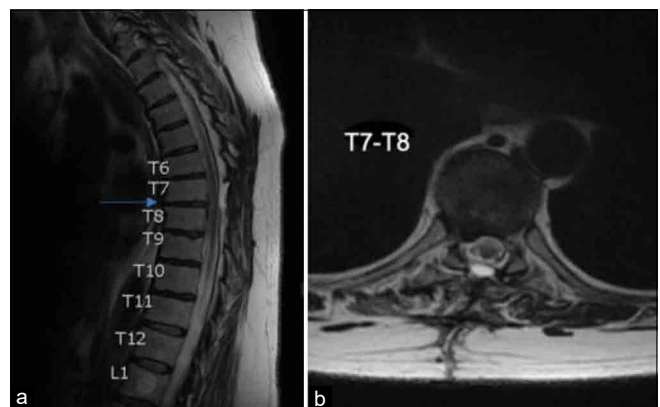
Postoperative MRI thoracic spine. (a) Sagittal view; arrow pointing to the level of the prior spinal cord herniation at T7-8, (b) Axial view at the level of the spinal cord herniation T7-8.
